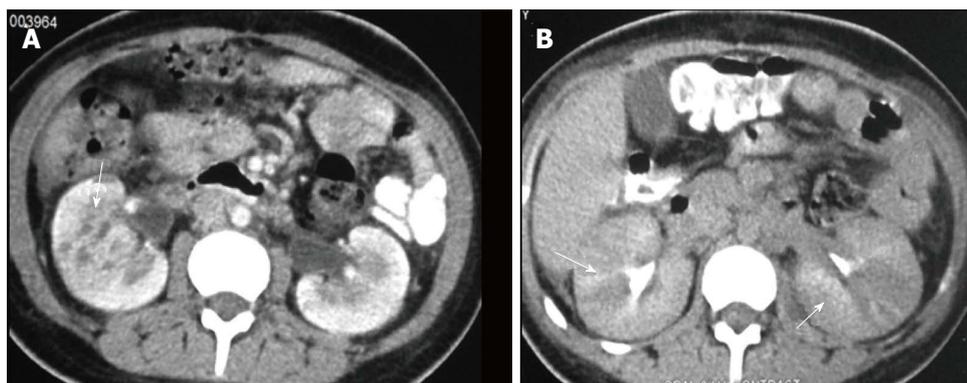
Acute pyelonephritis. A: CECT venous phase shows heterogeneous parenchymal enhancement with pelvic wall thickening (arrow); B: CECT delayed phase shows alternating discrete rays of hyper and hypoattenuation (arrows) giving the appearance of a striated nephrogram. CECT: Contrast-enhanced computed tomography.
